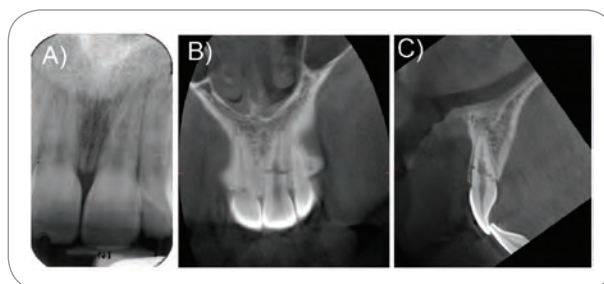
Periapical radiograph (A), sagittal (B), and cross-sectional (C) CBCT images of tooth No. 9.
